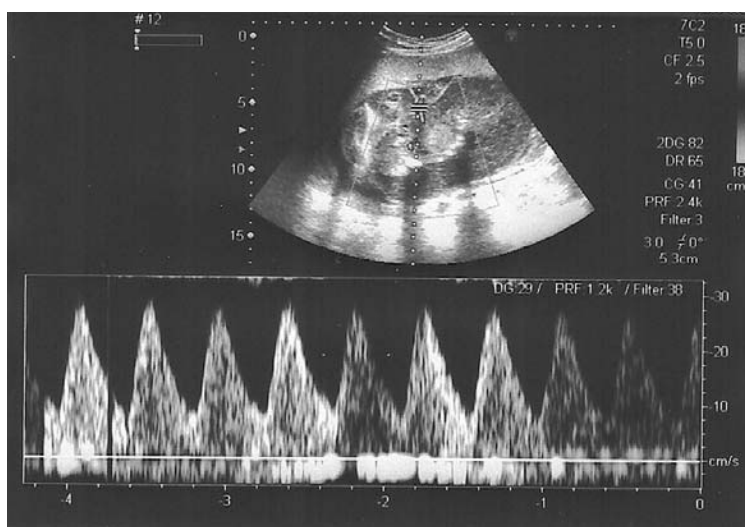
Blood flow of the acardiac twin on Doppler ultrasonography at 18 weeks of gestation.
